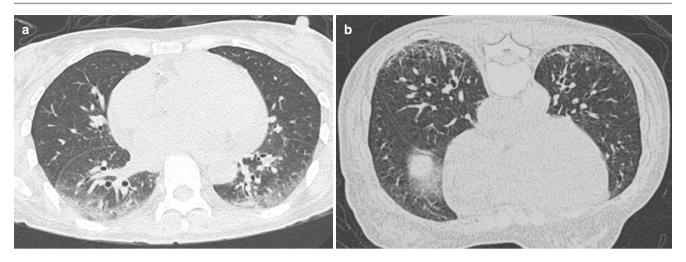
Utility of prone images. (a) Supine axial CT image shows symmetrical GGOs in the posterior basal region. (b) Prone image reveals fine reticular opacities along with GGOs and early traction bronchiectasis confirming early ILD in this patient with SLE
